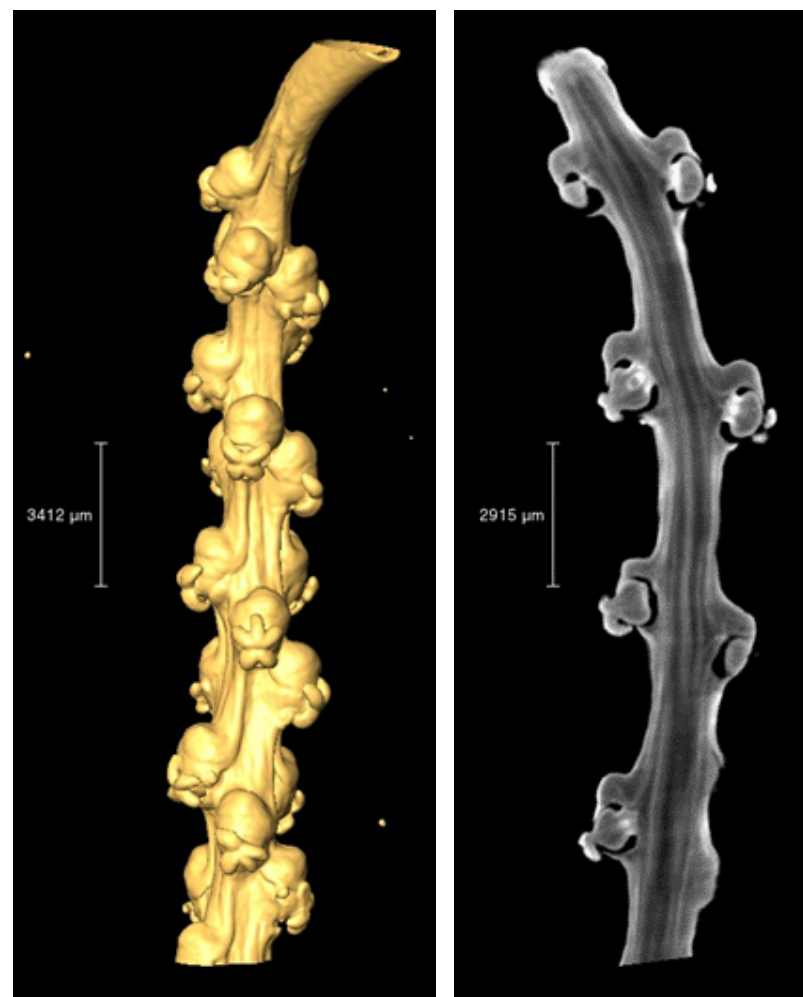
Microcomputed tomography images of a black pepper inflorescence showing numerous small flowers
